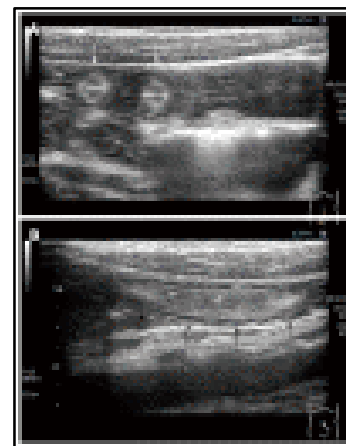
Ultrasound appearance of Ascaris (round worm) in the intestinal lumen
